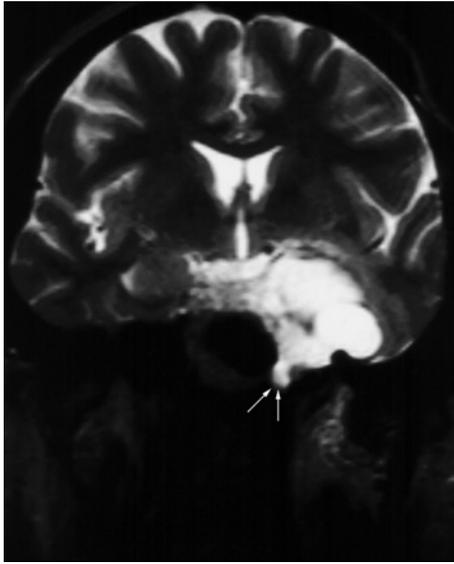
Chondrosarcoma of the left petro-clival suture, highly hyperintense on the coronal T2-weighted image. Left cavernous sinus and internal carotid artery are involved. Downward extent toward the nasopharynx is shown (*arrows*)
